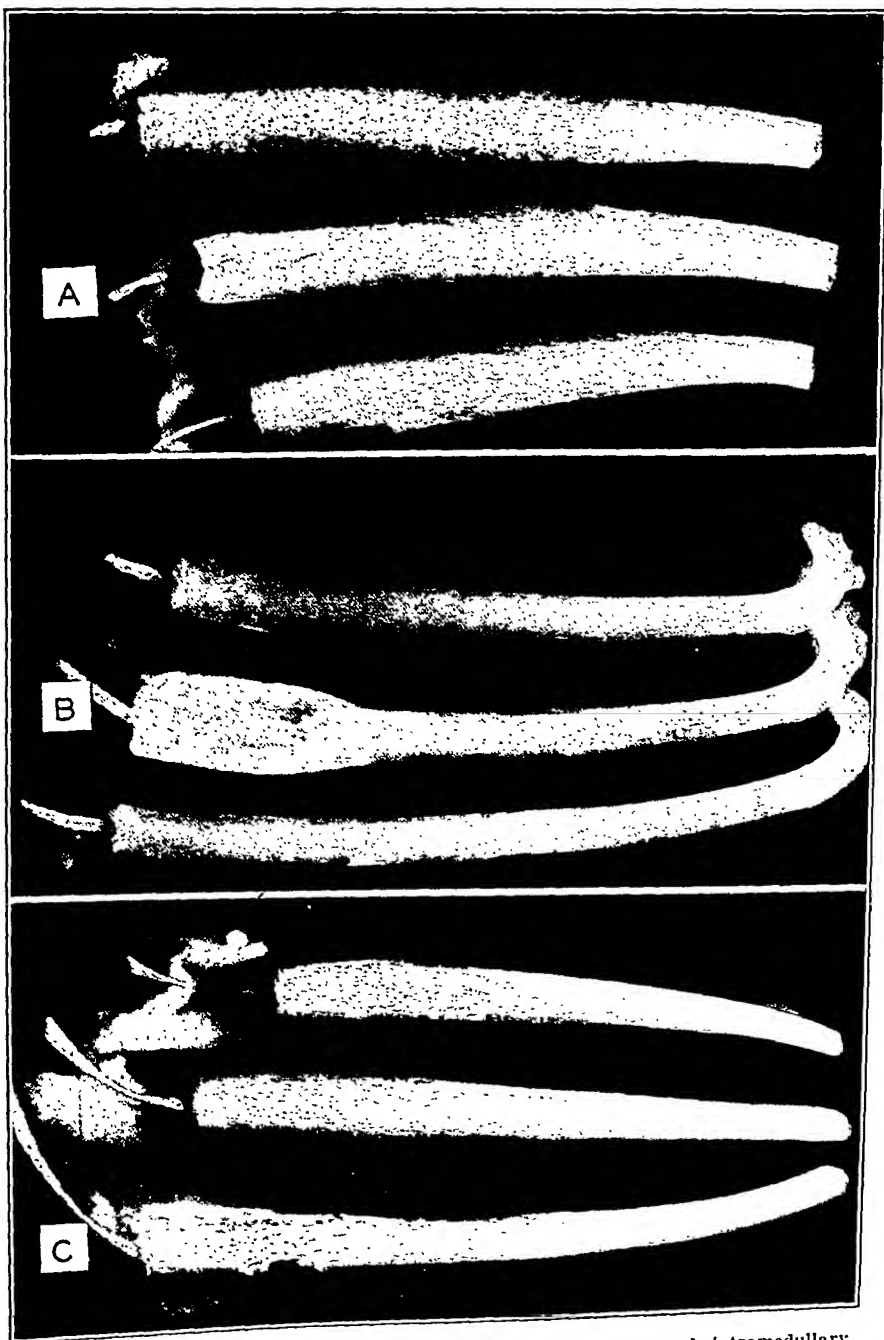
A, X-ray of adult ribs forty-one days after increased intramedullary pressure followed by 1 c.c. of nontoxin-producing staphylococcus culture. There is a small area of rarefaction, surrounded by bone of increased density. B, X-ray of the same rib as shown in Fig. 7 to show the bone destruction, involucrum, and sequestration. C, X-ray of adult rib nineteen days after elevated intramedullary pressure followed by the intravenous injection of toxin-producing staphylococci. The amount of bone destruction and new bone formation is evident.
